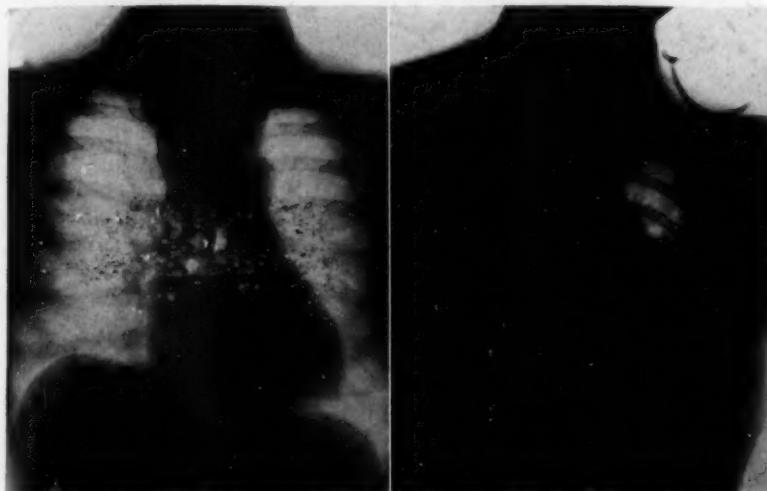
(case 3).—Roentgenogram of lungs in a case of atelectasis following thyroidectomy; A—roentgenogram made on admission of patient to hospital and B—roentgenogram made after development of symptoms of atelectasis. The consolidation in the lower lobe of the left lung and in the middle and lower lobes of the right lung should be noted.
